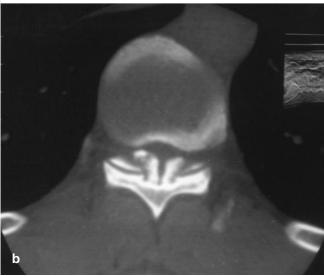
a Magnetic resonance imaging, axial T2-weighted image at T10–T11; b computerized tomography, axial scan with bone window at the same level. Severe stenosis of the spinal canal due to the V-shaped ossified yellow ligament can be seen
